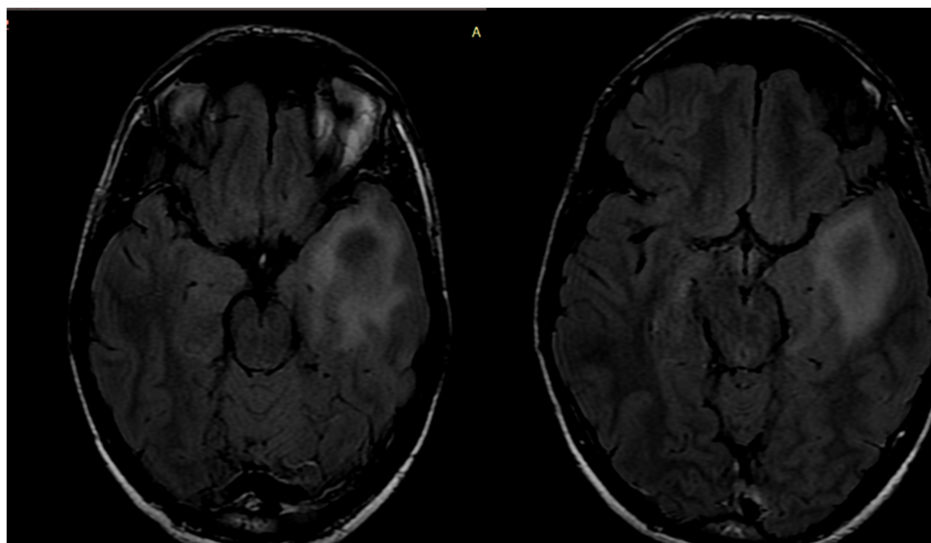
Preoperative T2 FLAIR signal.
